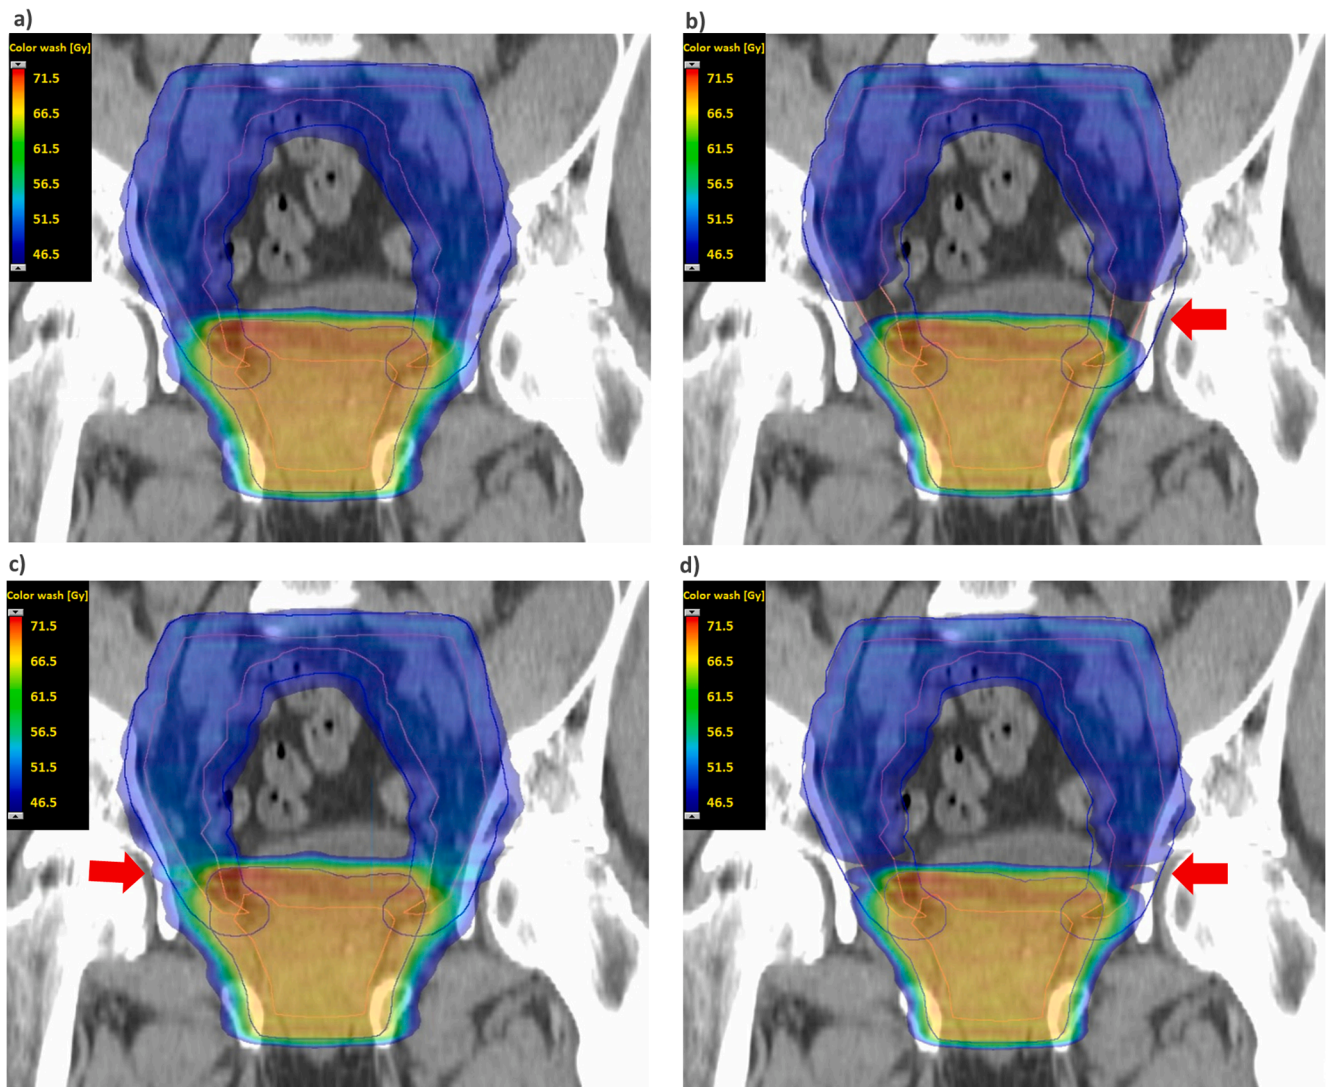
Computed tomography images (frontal views) showing summed dose distributions in phases 1–3. a) Dose distribution expressed as physical dose when physical dose is used in the base plan. All target objectives are fulfilled. b) As in a) but in terms of the EQD2-corrected dose, showing lower target coverage in the inter-phase junction (red arrow). c) Dose distribution expressed in physical dose when using the biologically adaptive base plan. All target objectives are met, but with a slightly increased dose in the inter-phase junction (red arrow). d) As in c) but in terms of the EQD2 corrected dose, showing improved dose coverage in the inter-phase junction, and without the hotspots observed in c) (red arrow).
